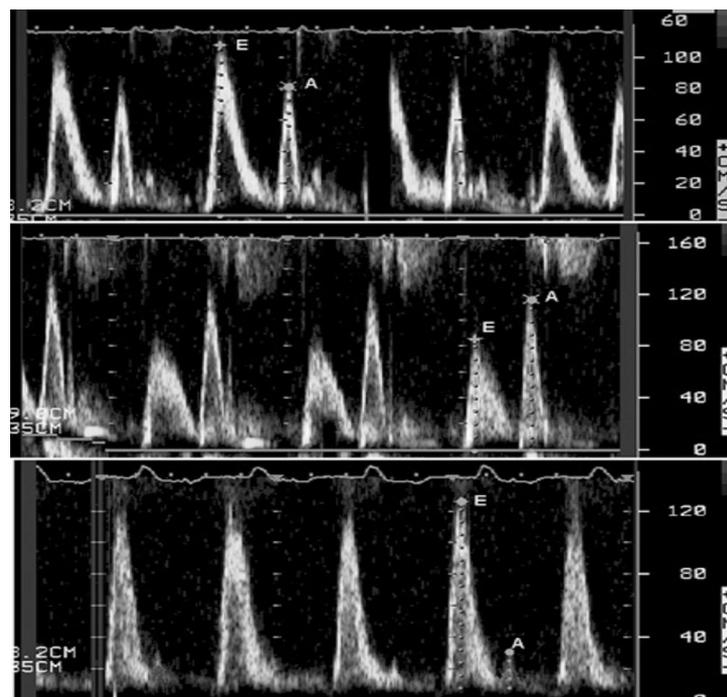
Trans-mitral valve spectral Doppler flow pattern in a normal subject (upper panel), in a patient with mild diastolic dysfunction (abnormal relaxation; middle panel), and in a patient with severe (restrictive) diastolic dysfunction (lower panel) In the upper panel, the *E/A* wave ratio is approx. 1.5 to 1.0, and in the middle panel the *E/A* wave ratio is <1.0 . In the lower panel, the *E/A* wave ratio is abnormally high and *A* wave velocity is very low. (Source: Uusitupa *et al.*, 1988).
